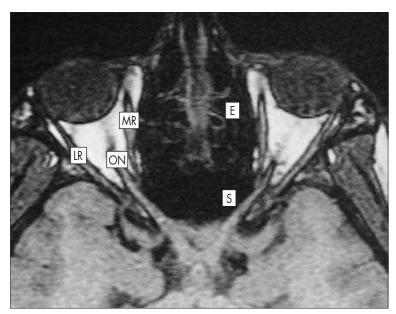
Axial MRI Scan Through the Midorbit. The section is slightly higher than in Fig. 12.3.2. The optic nerves are seen passing back to the optic chiasm. *E*, Ethmoid sinus; *LR*, lateral rectus; *MR*, medial rectus; *ON*, optic nerve; *S*, sphenoid sinus
